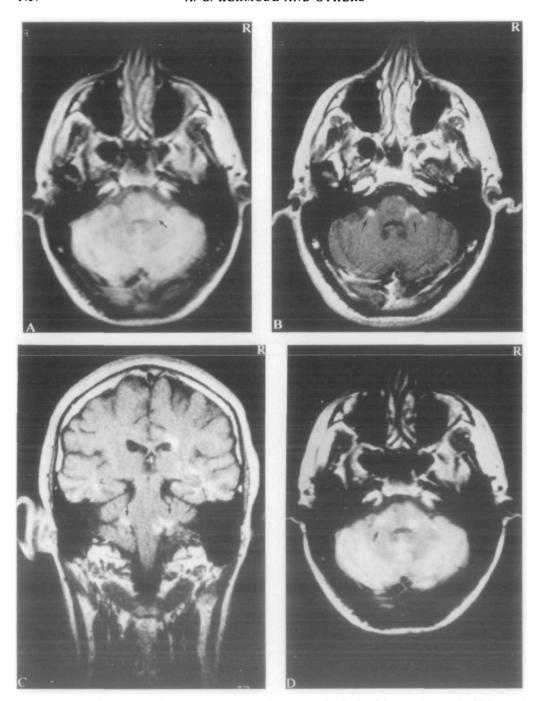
A, unenhanced T_2 weighted MRI (SE $_{2000/40}$) showing a lesion in the right pons (arrowed) which extends to the root entry zone of the right acoustic nerve. B, T_1 weighted Gd-DTPA enhanced MRI (SE $_{500/40}$) several minutes later showing enhancement (arrowed) in both the right and left root entry zones of the eighth nerve. c, coronal T_1 weighted Gd-DTPA enhanced MRI (SE $_{500/40}$) taken immediately after B, also demonstrating the bilateral enhancement (arrowed). D, unenhanced T_2 weighted MRI (SE $_{2000/40}$) 1 month later which clearly shows a lesion in the left root entry zone.
